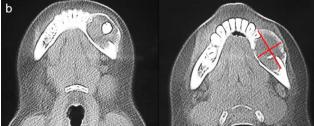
a- Panorex showed extensive unilocular, radiolucent lesion of left mandibular body and including the second premolar inside the lesion, b- CT axial views of bone window, the dimensions of the lesion were: 3.6 cm antero-posterior and 2.3 cm width.
